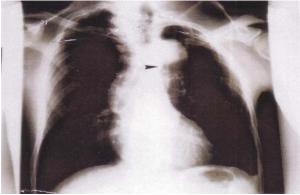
Chest X-ray-Coarctation of aorta in MRKH type-II
